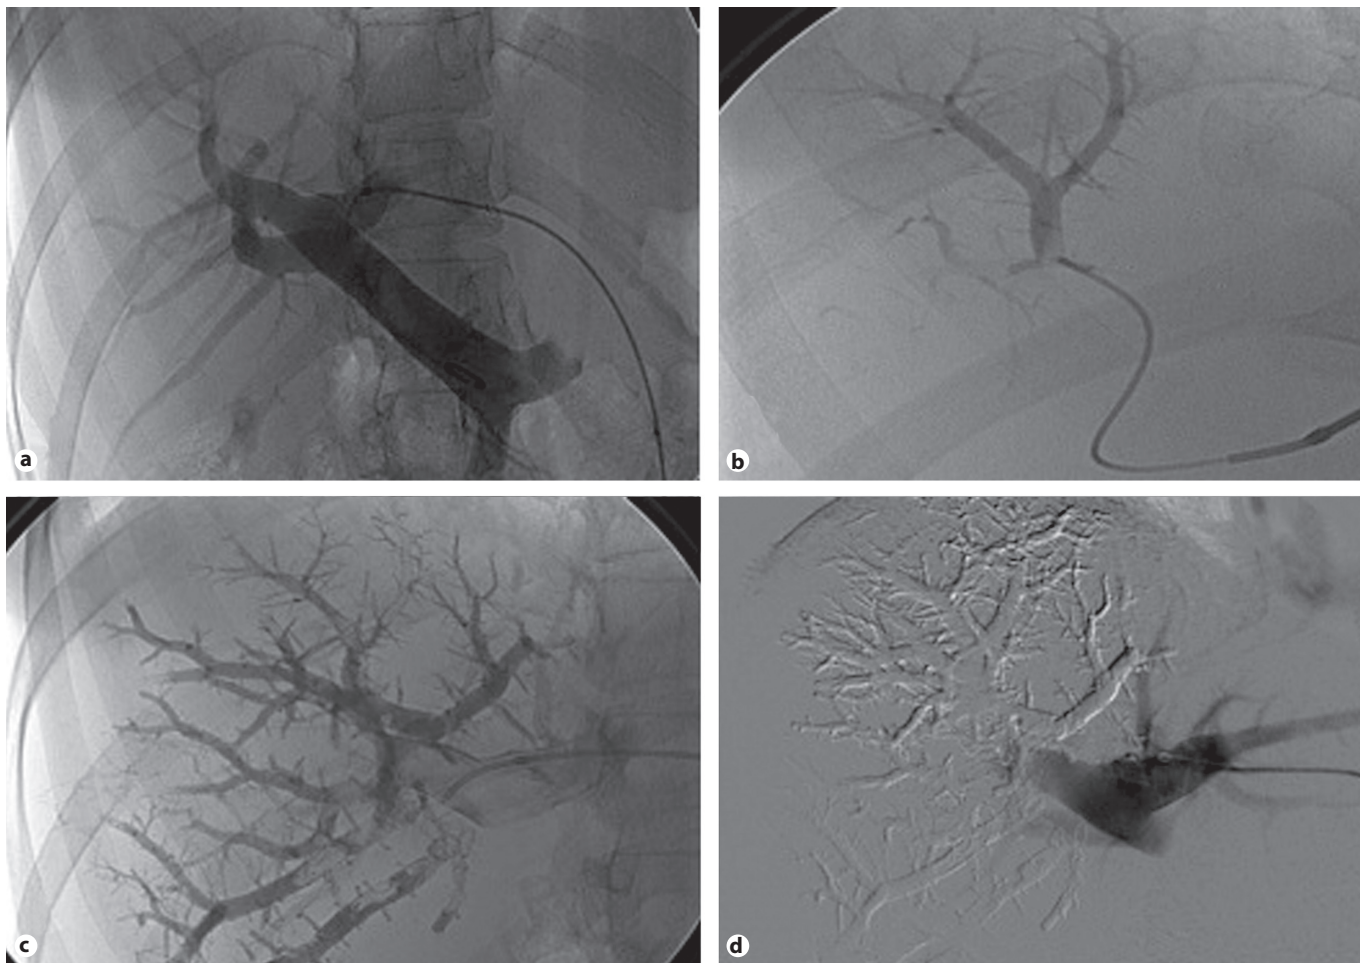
a Placement of a pigtail catheter in the main portal branch after CT-guided puncture of the left portal vein. b Catheterization of a right-sided portal branch via a microcatheter system. c, d Visualization of the entire embolized area of the right-sided portal branches. 228 × 160 mm (300 × 300 DPI).
